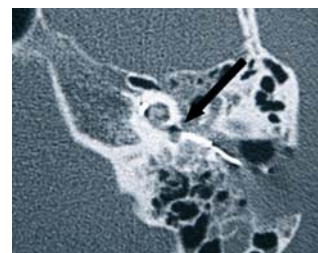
Patient 2; postoperative axial CT scan with partially removed promontory (arrow).
